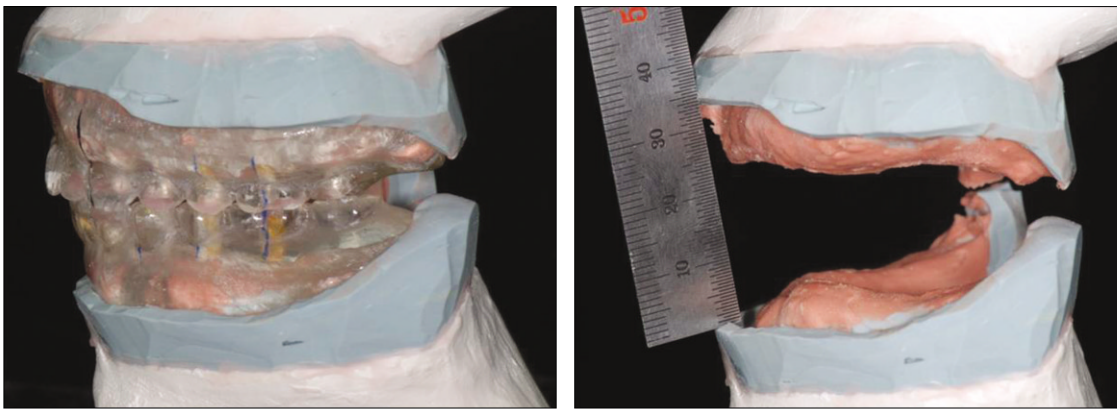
Radiographic stents duplicated from the provisional dentures (left), and measurement of occluso-vertecal arch relationship (right).
